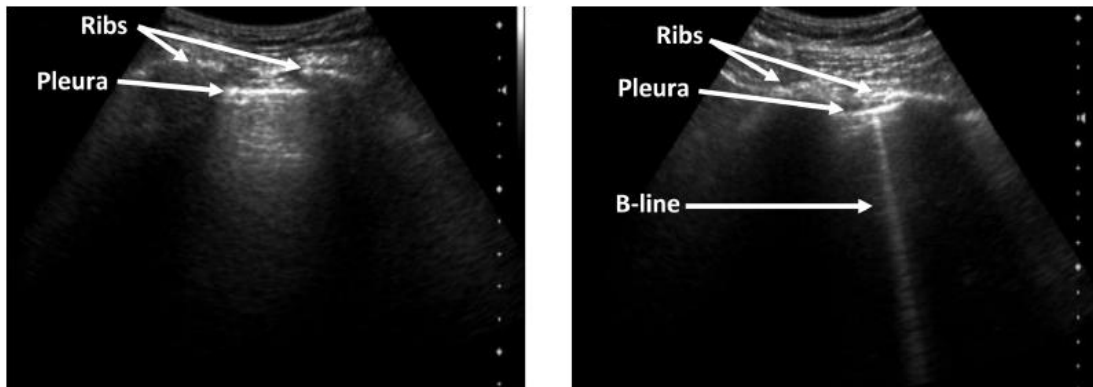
Ultrasound appearance of the ribs, pleural line and B lines.
